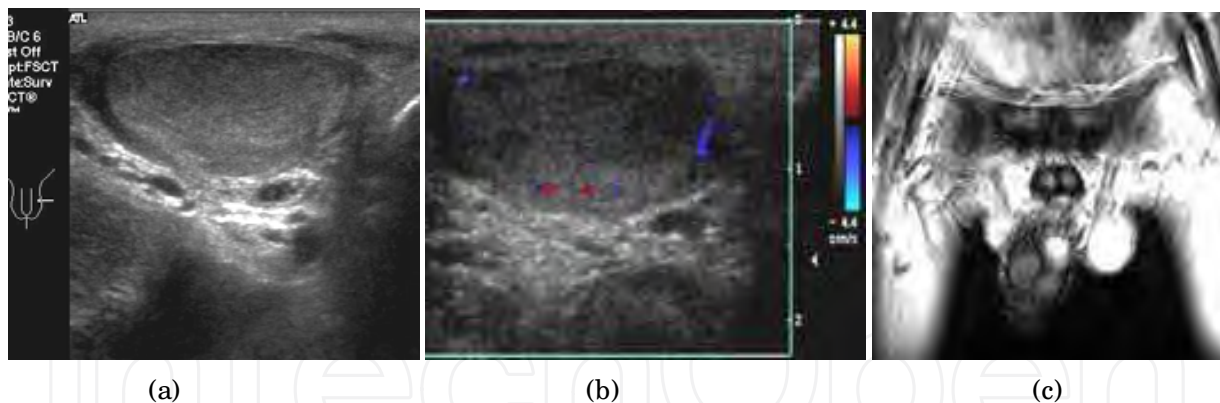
A 26-year-old male sustained blunt scrotal injury and presented with left scrotal pain. (a) A transverse sonographic scan showed mild heterogeneous change of the left-sided testis. (b) There was a marked decrease in blood flow to the affected testis. (c) Magnetic resonance imaging: normal testicular perfusion and shape 1 day after the initial sonographic study
